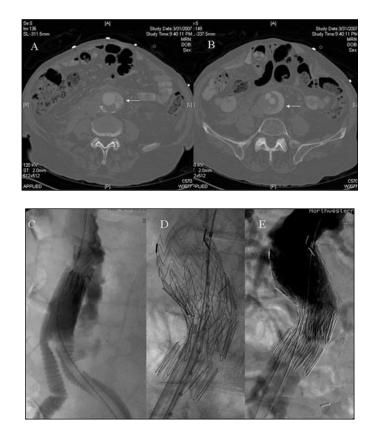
(A) CT scan at the level of the proximal anastomosis of a Dacron graft surgically placed nine years prior. Contrast is seen outside the graft and into the sac (arrow). The sac was previously treated with endoaneurysmorrhaphy. (B) A lower cut showing contrast and thrombus in the aneurysm sac outside the limbs of the graft. (C) Angiogram demonstrating the equivalent of a Type 1 endoleak at the proximal anastomotic site. A proximal aortic cuff (Zenith) is being deployed. (D) A combination of different aortic cuffs (Zenith,Excluder) was needed to correct the radiographic abnormality. (E) Completion angiogram showing patency of both renal arteries and elimination of the endoleak.
